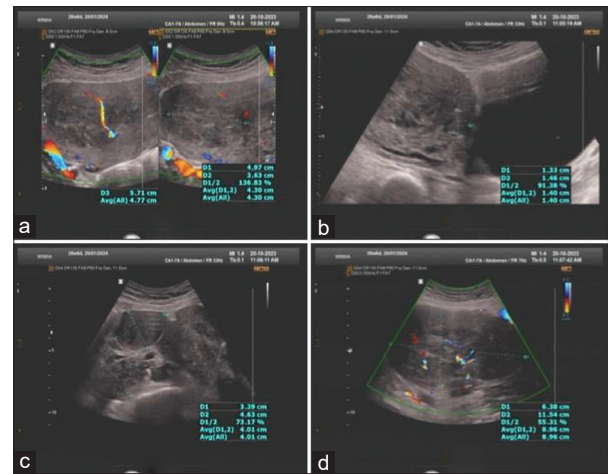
Ultrasound findings show as following. (a) A heteroechoic uterine intramural mass measured at 49 mm × 36 mm × 57 mm in size with the presence of Doppler signal, (b) The other disseminated masses with the same characteristics, variable diameters from 13 mm × 14 mm × 14 mm to 34 mm × 45 mm × 46 mm, (c) In the right pelvic cavity, along with the left iliac artery, some cystic solid mixed masses varied from 20 mm × 40 mm to 40 mm × 50 mm in size, (d) Above the umbilicus, a paraaortic hypoechoic mass measuring 63 mm × 93 mm × 115 mm with proliferative vascular grade 3 was found
